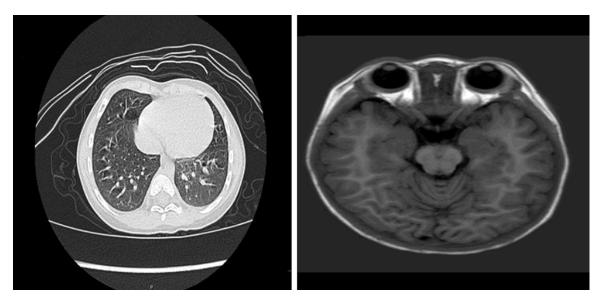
The chest CT scan and cranial MRI were all normal after following up 3.5 years of case 1.
